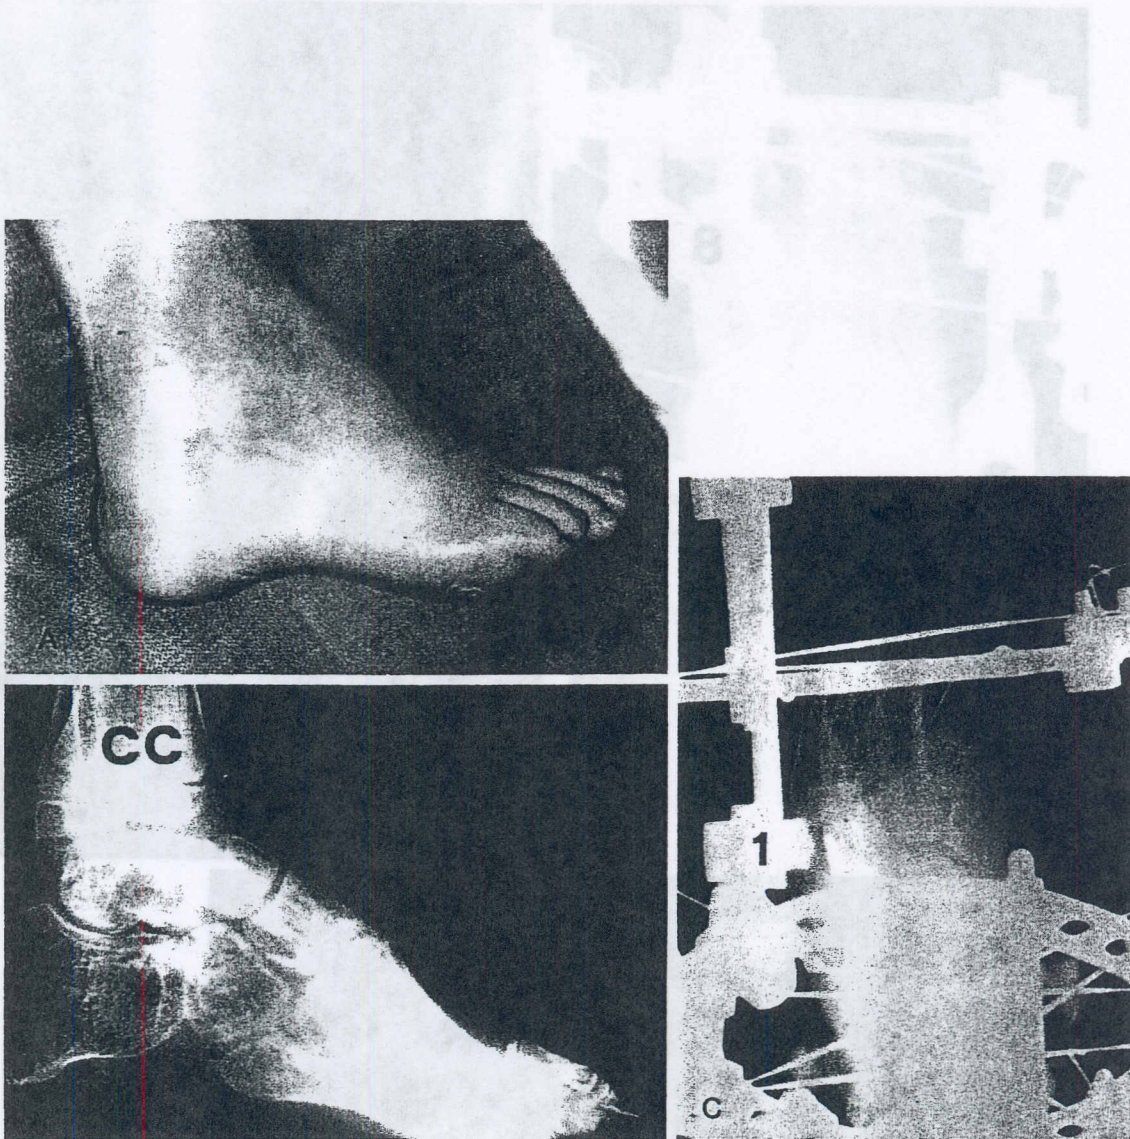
(A and B), Preoperative photograph and radiograph demonstrating forefoot cavus secondary to a previously treated clubfoot deformity. (C), An osteotomy was performed across the cuboid and cuneiforms. Because of the lack of constraint, the distraction force led to separation of the adjacent joints. The osteotomy never separated.
